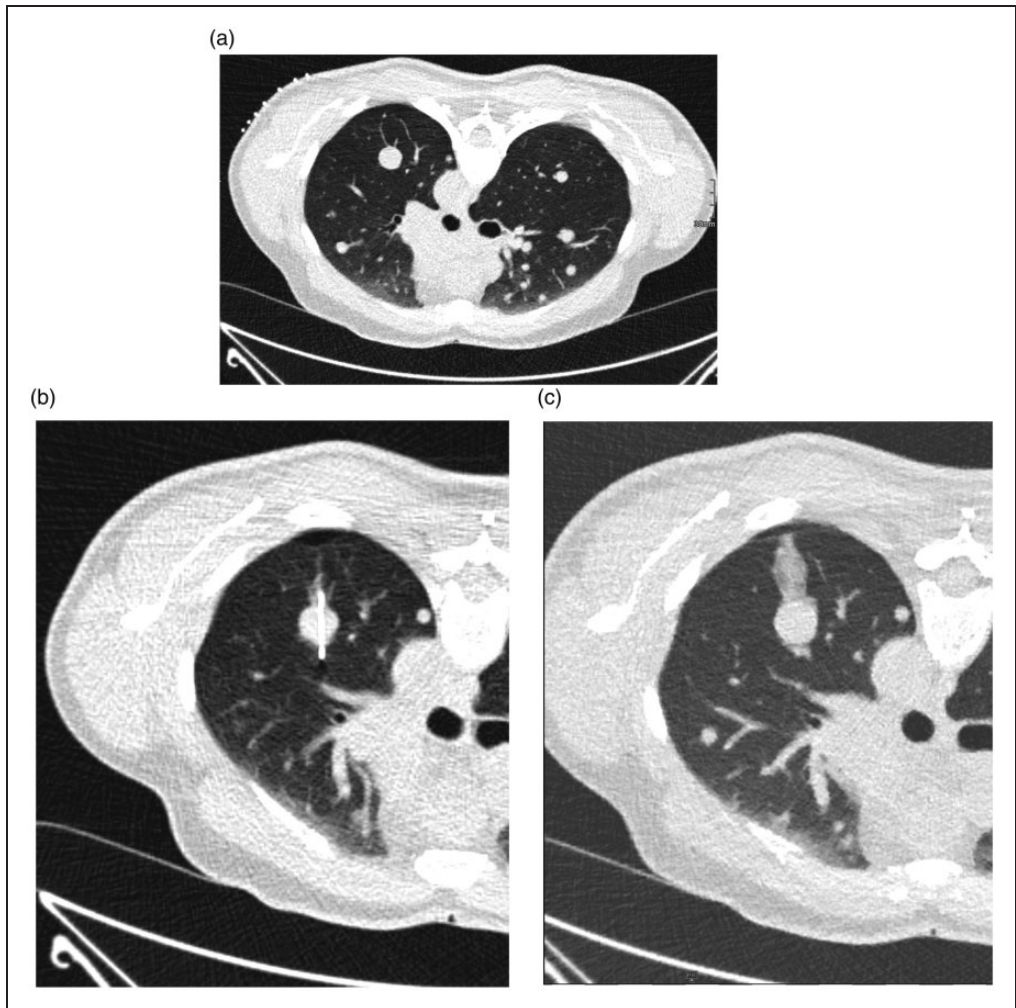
A 65-year-old man (body mass index 28 g/m^2) with suspected pulmonary metastases of malignant melanoma underwent ultra-low-dose computed tomography. Total radiation dose (dose-length product, DLP, $35.1 \text{ mGy} \times \text{cm}$) with a total effective dose of 0.5 mSv (calculated by CT-Expo: Stamm G, Nagel HD. CT-Expo – a novel program for dose evaluation in CT *Fortschr Roentgenstr* 2002;174:1570–1575). (a) Preinterventional planning sequence. (b) Correct needle position in the lung nodule. (c) Post-puncture hemorrhage in the needle pathway as a physiological consequence and small post-interventional pneumothorax without therapeutic consequence.
